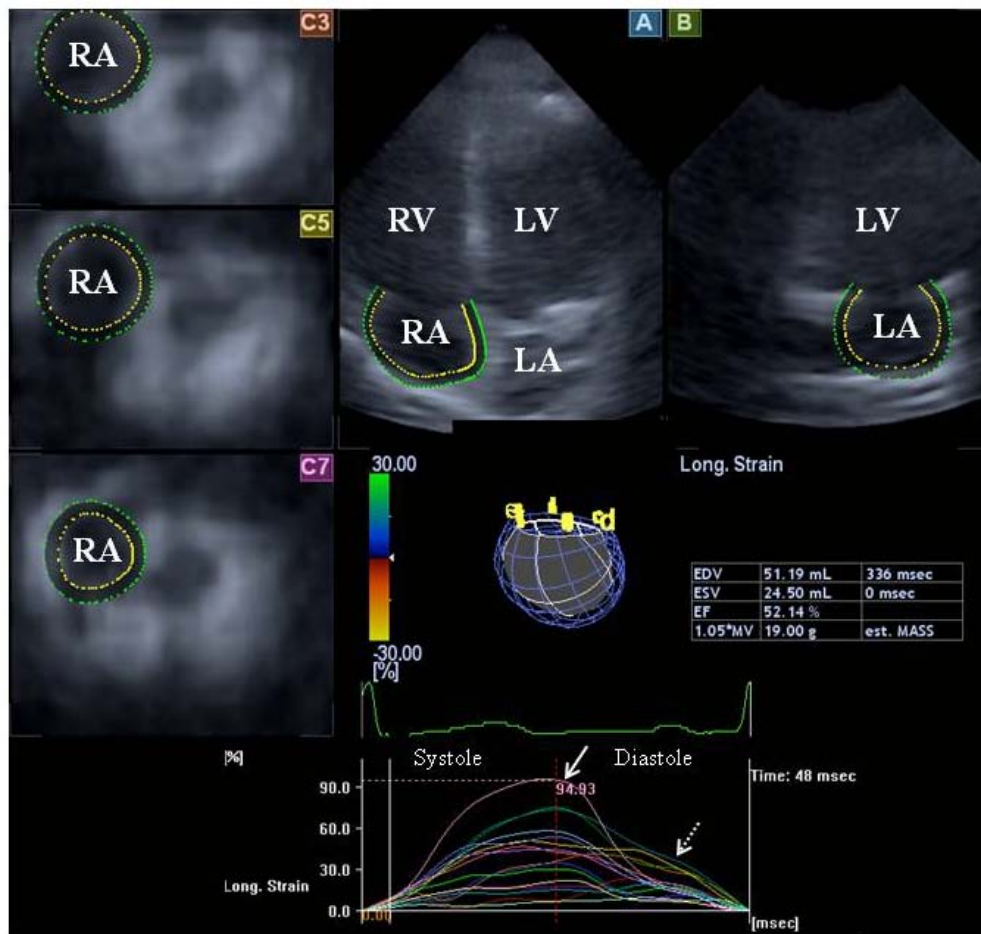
Images from three-dimensional (3D) full-volume dataset showing right atrium (RA) in a healthy subject is presented: (A) apical four-chamber view, (B) apical two-chamber view, (C3) short-axis view at basal, (C5) mid- and (C7) superior RA atrial level. A 3D cast, volumetric data, time – segmental strain curves of the RA are also presented. White arrow represent peak segmental strains, while dashed arrow represents strains at atrial contraction.
